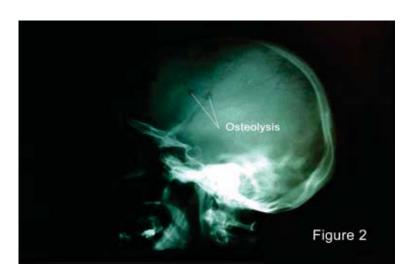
and Figure 2. Cranian radiography - face and profile. Areas of bone resorbtion frontoparietotemporally. Clinical case. M.E., 54-year-old; personal collection
